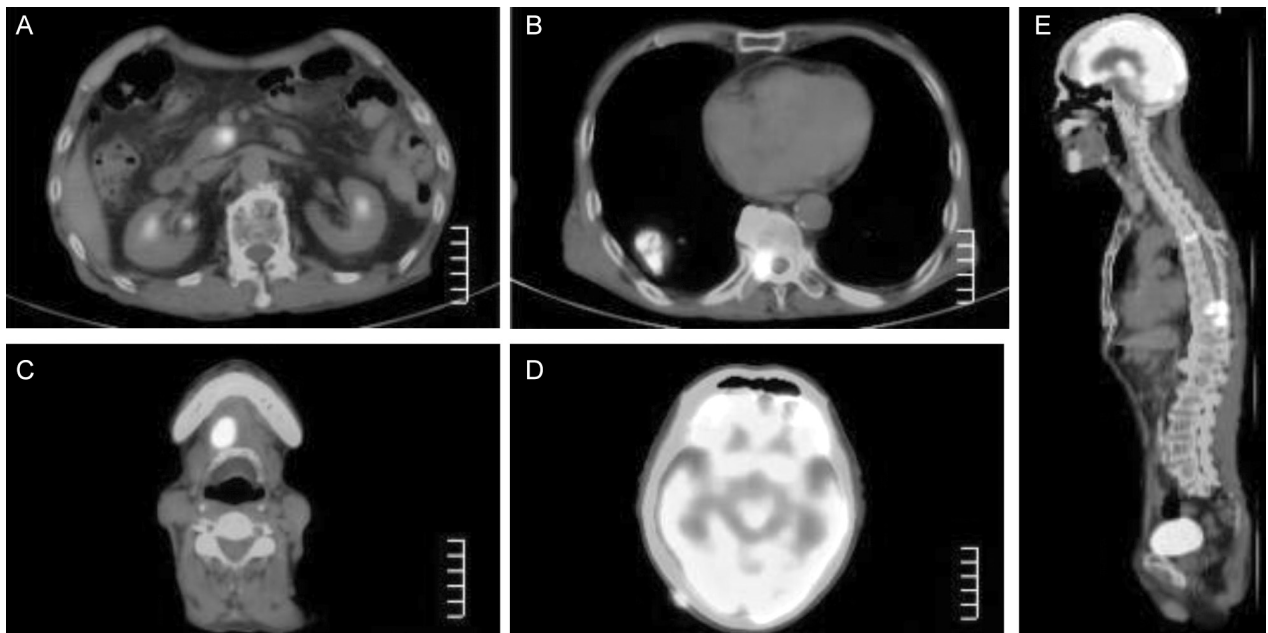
Whole body PET-CT. A. Parenchymal organs; pancreas, body (mSUV 4.91). B. Right lower lung (mSUV 6.19). C. Right submandibular (mSUV 3.37). D. Bones; skull (mSUV 6.96 at the highest). E. T4, 9, 10, sacrum (mSUV 6.12 at the highest).
